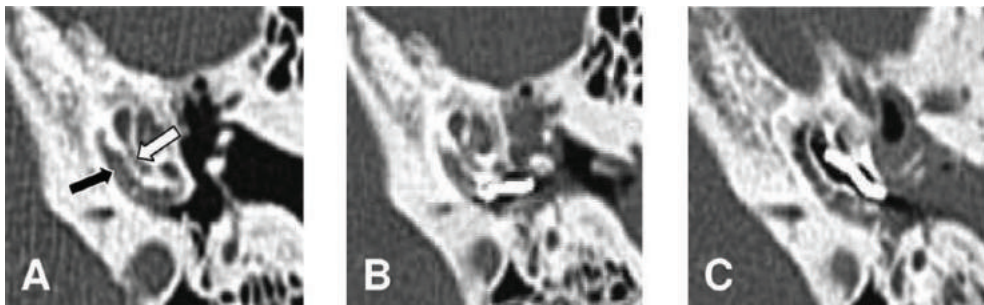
Axial computed tomography (CT) scan of the petrous bone in a patient with retrofenestral otosclerotic lesions: pre-, peri-, and postoperative. (A) Preoperative CT scan: grade 2C retrofenestral otosclerosis (according to Rotteveel classification): double ring (black arrow) and basal turn narrowing (white arrow). (B) Perioperative CT scan of the same patient with the electrode entering a false lumen due to the thickened round window, sclerotic scala tympani, and otospongiotic double ring surrounding the cochlea. (C) Postoperative CT image with a complete electrode insertion in the scala vestibuli.
